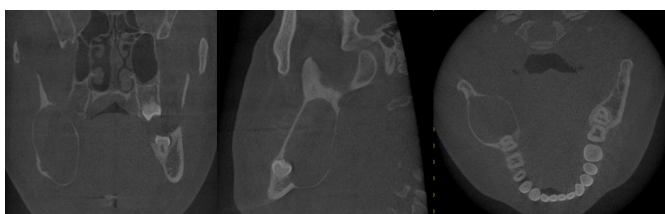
Preoperative CBCT. Expansion of the buccal and lingual cortices.
